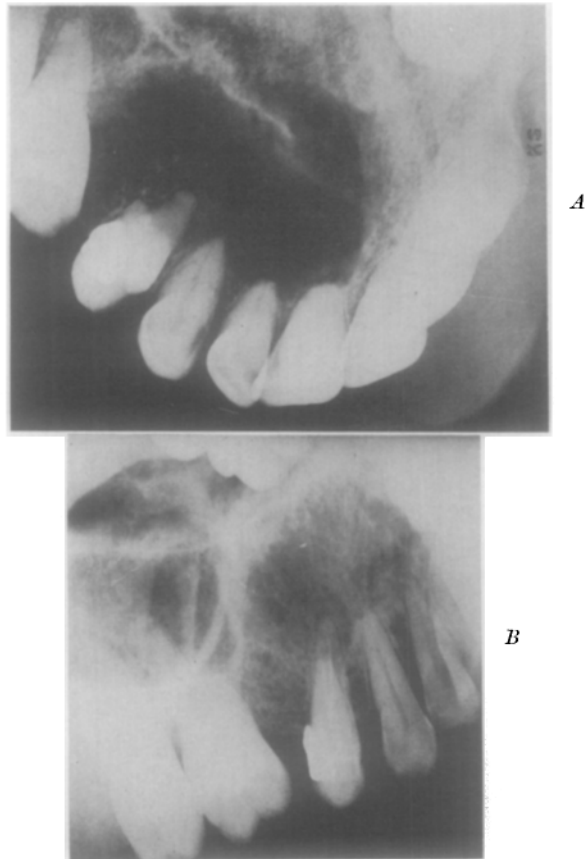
A, Occlusal roentgenogram showing location and extent of lesion. B, Intraoral roentgenogram made 15 months after initial treatment.
